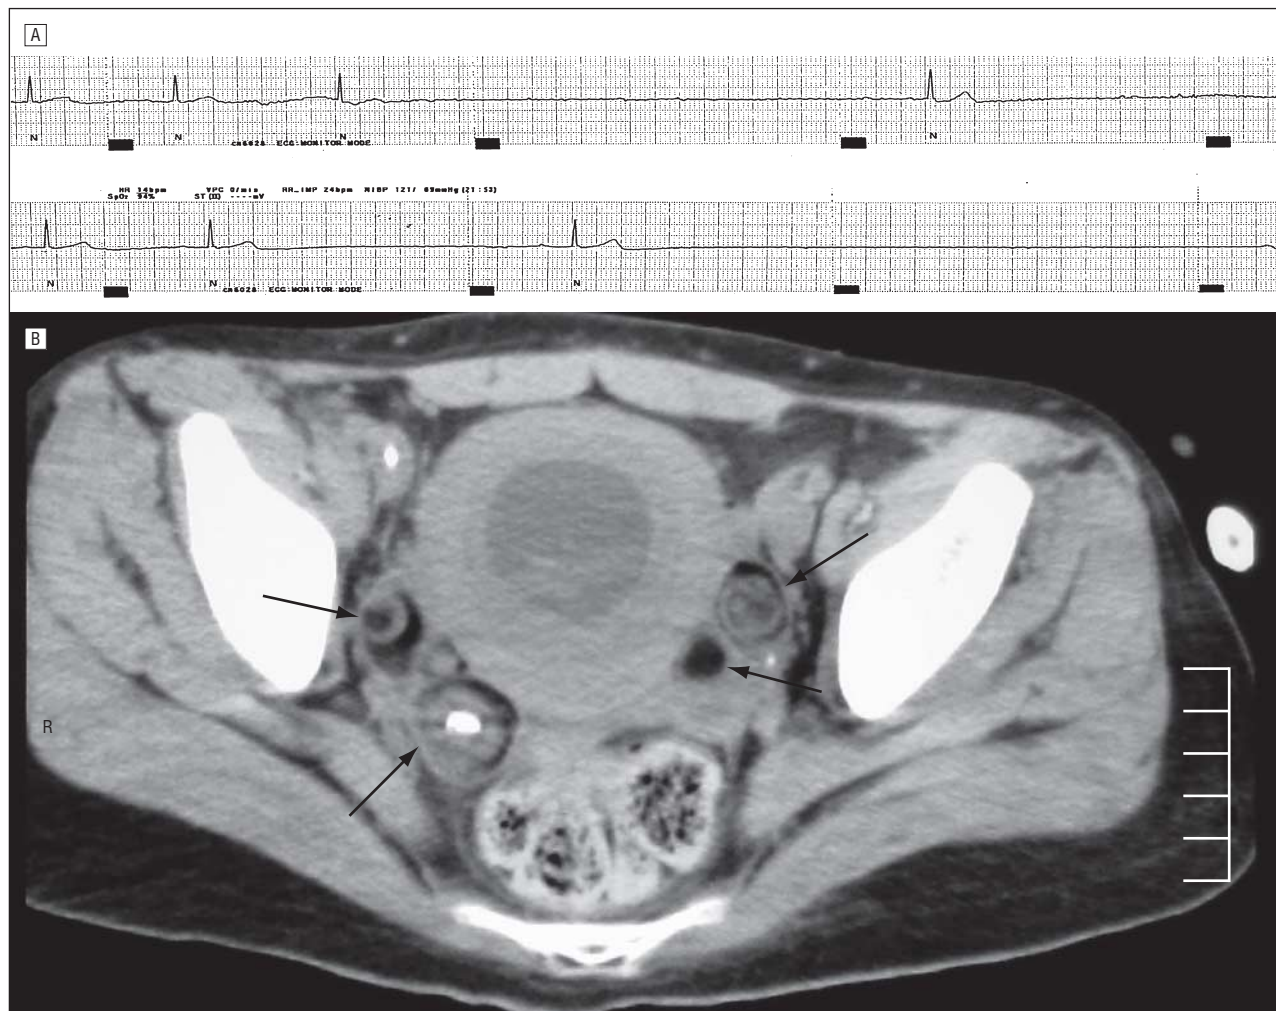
Cardiac pauses and bilateral teratomas in patient 2. A, Cardiac pauses up to 5 seconds were noted on day 3 of hospital admission. B, A pelvic computed tomographic scan revealed bilateral recurrent teratomas (arrows).
